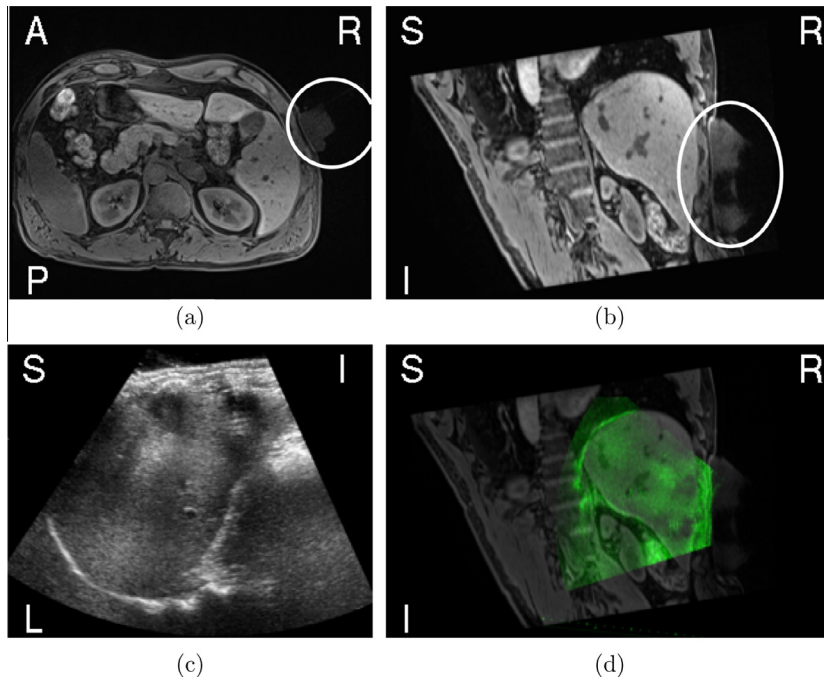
(a) Apnea slice with transducer highlighted on the right. (b) Slice through the apnea image corresponding to the US plane with transducer highlighted. (c) Ultrasound image. (d) MR and US images aligned and overlaid.
